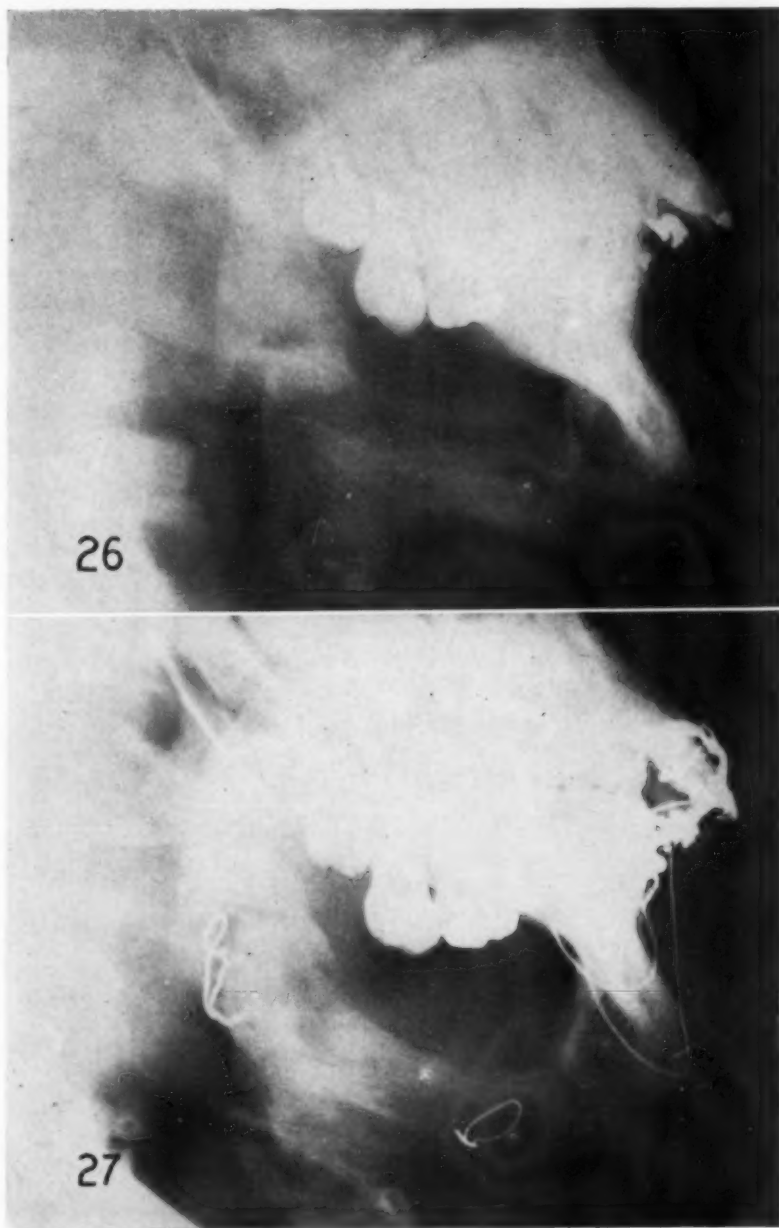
(Case 6).—Radiograph showing defect in left side of mandible and remains of unsuccessful rib graft.
